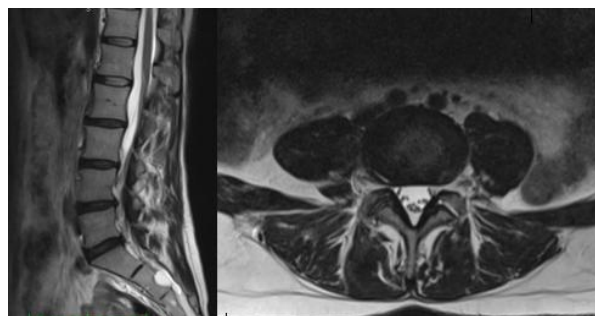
Lumbar MR images of patient was evaluated due to RP
